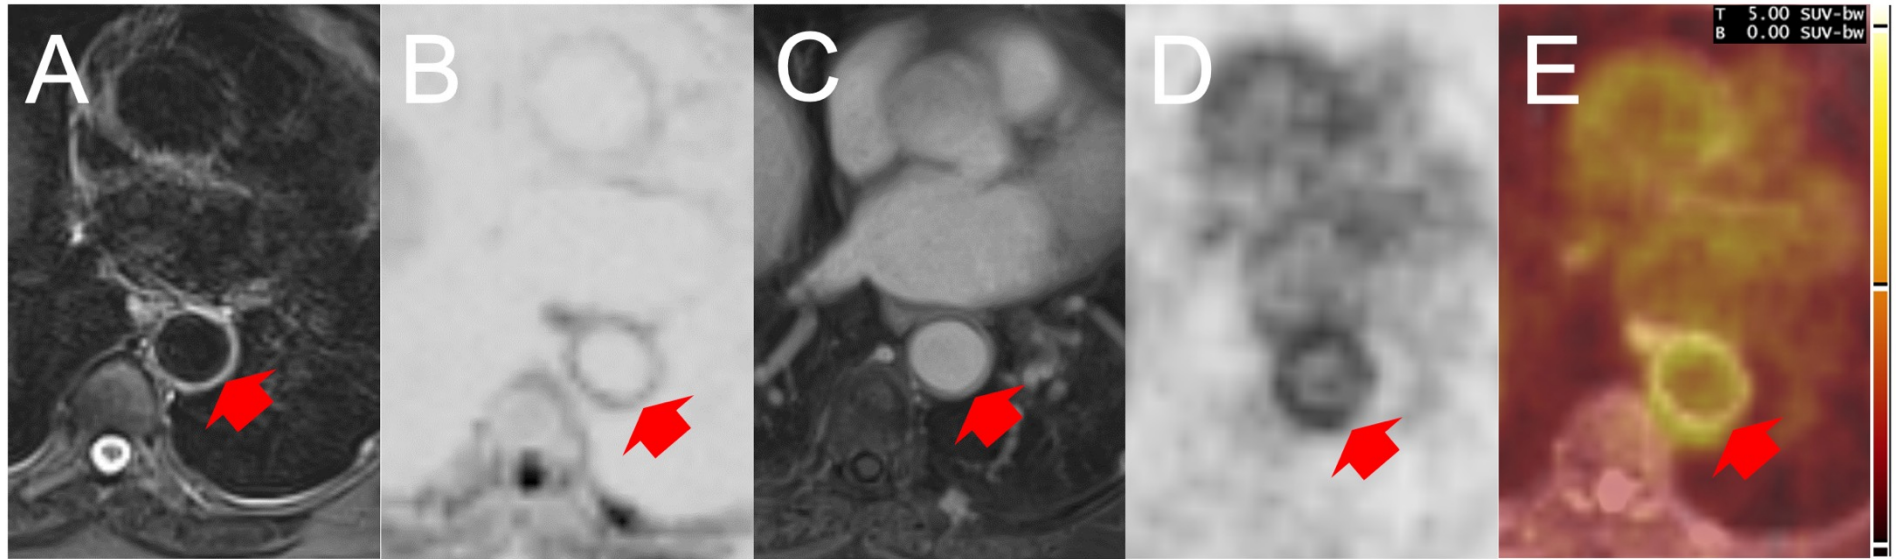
Findings rated positive for large vessel vasculitis in the descending aorta on MRI and FDG-PET/CT: MRI shows oedema on both T2w fat-suppressed (A) and low b-value diffusion weighted sequences (B) accompanied by wall thickening and gadolinium enhancement on post contrast T1w GRASP (C). PET shows increased FDG uptake in the identical position (D). Figure (E) is a PET/MRI image fusion of the corresponding images (B) and (D) (Image fusion with Siemens SyngoVia version VB40). Red arrows highlight vessel wall oedema, contrast enhancement and increased FDG uptake, respectively.
